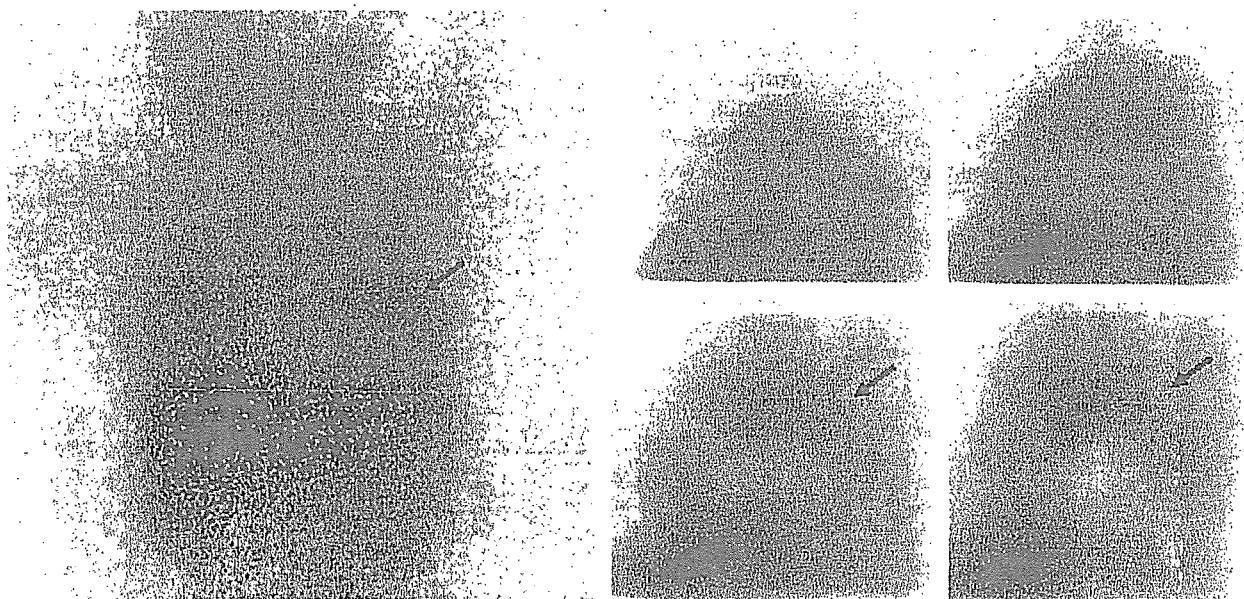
Anterior planar and short-axis single-photon emission computed tomography images with iodine-123 metaiodobenzylguanidine (MIBG) 4 hours after injection. Regional MIBG uptake is seen in the basal anterior left ventricle (arrows) 6 months after the cardiac transplantation.
